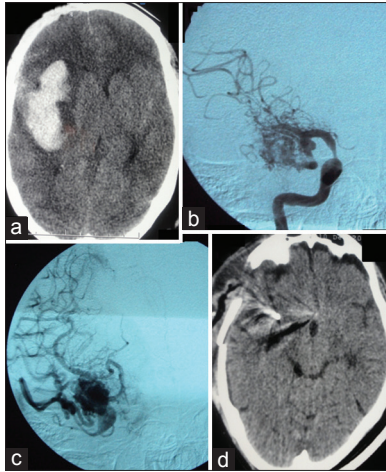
Patient 4 - (a) Plain computed tomography (CT) axial images showing frontotemporal perisylvian bleeding with midline shift, (b) AP view of right internal carotid artery digital subtraction angiogram showing the right temporal and perisylvian high flow arteriovenous malformation (AVM) (Spetzler Martin grade 3; size 2, venous drainage = 0, eloquence = 1) supplied by M2 and M3 branches of right middle cerebral artery with an intranidal AA, (c) The venous drainage into superficial cortical vein, (d) Postoperative contrast axial CT scan showing the aneurysmal clip artefact and total AVM excision
